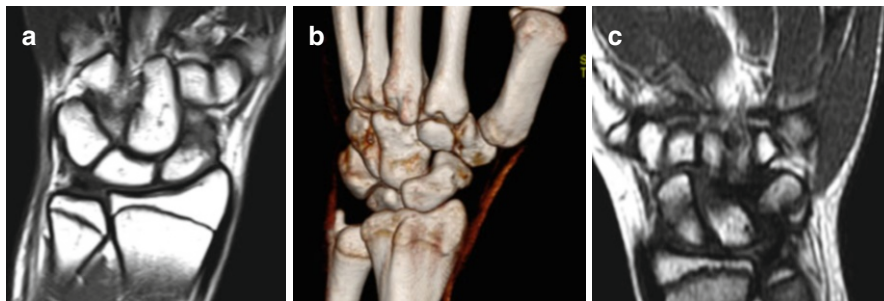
Scaphoid fracture in a 16-year-old-basketball player occurred after a direct blow to the palm. (a) T1-weighted image on the coronal plane shows an inhomogeneous aspect of the distal scaphoid pole, characterized by a diffuse area of low signal intensity, with a subtle fracture within it. (b) VRT reconstruction on the coronal plane shows the irregular presentation of the distal pole, finding suggestive of fracture. (c) Fracture of the body scaphoid, misdiagnosed on plain film in a 10-year-old girl, occurred after a fall onto an outstretched hand. T1-weighted image on coronal plane shows a subtle linear image of low signal intensity at the middle aspect of the bone, suggestive of fracture
